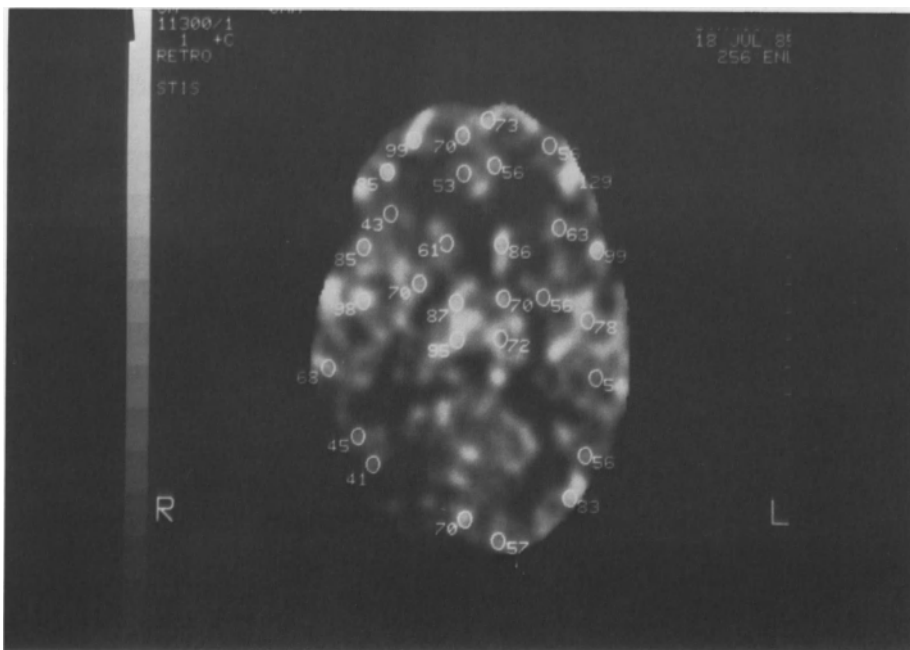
b. The scale is 0–150  $\text{cm}^3/100 \text{ g}/\text{minute}$ , and five-millimeters-in-diameter ROIs, which were selected from within gray matter regions on the CT image, are displayed
